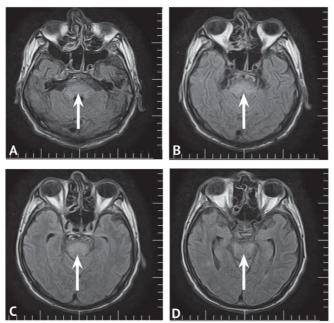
Magnetic resonance Tomo graphy patient brain P . On MRI of the brain, specific signs of CPM were revealed. A–D – T2-FLAIR, axial sections, arrows indicate high signal areas in the area of the brain bridge
